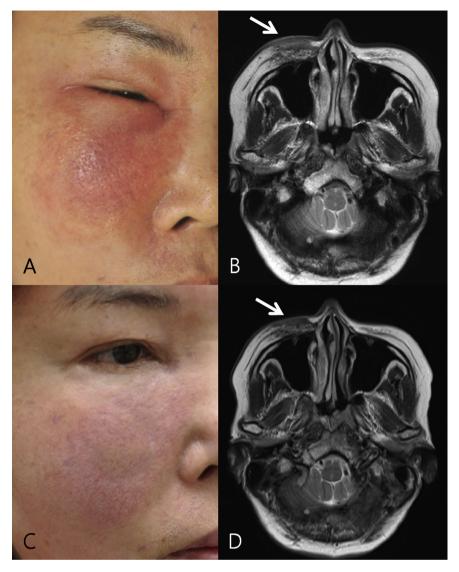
(A) Erythematous indurated plaque on the right cheek with swelling of periorbital area. (B) Magnetic resonance image (axial view, T2WI) revealing swelling and high signal intensity lesion at skin and subcutaneous fatty layer of right cheek (arrow). (C) After 6 months treatment, improved skin lesion and swelling on the right cheek with mild telangiectasia. (D) Decrease in swelling and high signal intensity lesion at skin and subcutaneous fatty layer of right cheek on MRI (axial view, T2WI).
